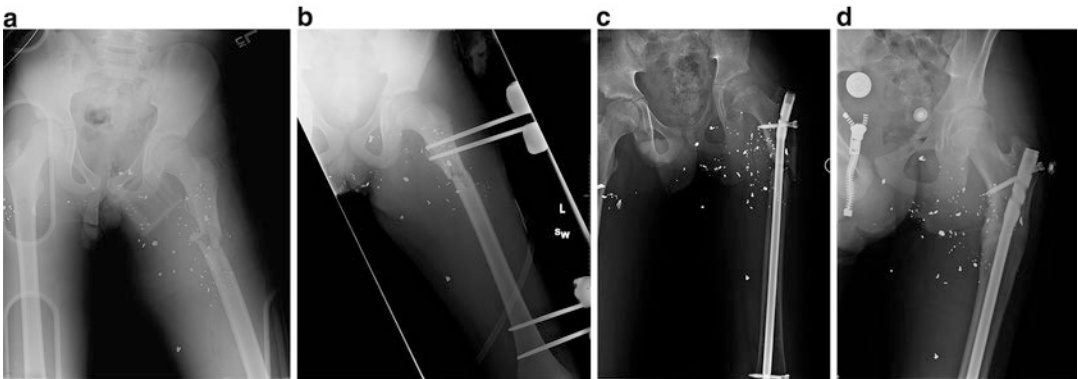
(a) Proximal femoral shaft fractured caused by gunshot. (b) Treated with external fixation. (c) Nonunion developed, and the patient was treated with intramedullary nailing. (d) Radiograph reveals fracture healing
